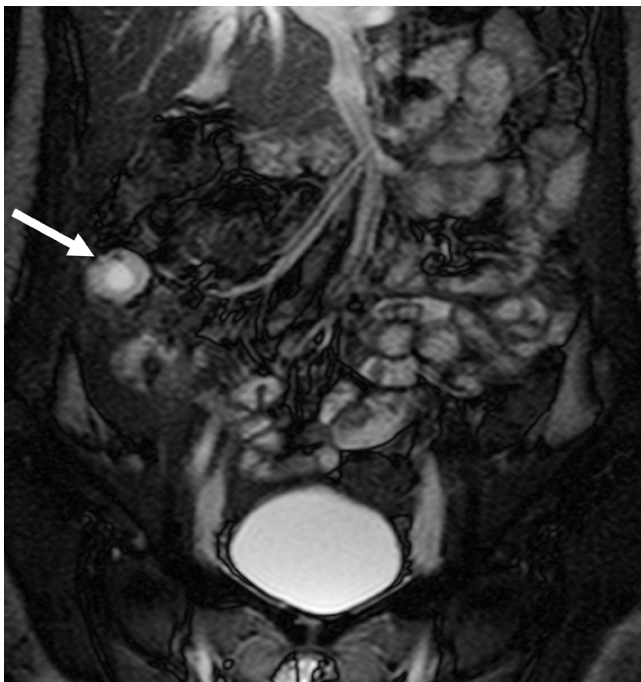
MR imaging finding in a 28-year-old woman with abdominal EP. Coronal T2-weighted imaging shows a well-defined cystic lesion with a thick peripheral wall (arrow) in the lateral aspect of the ascending colon, suggested to be the focus of the EP. Adapted from Kim et al. *Abdom Radiol (NY)* 2022;47:2254-2276, with permission of Springer Nature (20). EP = ectopic pregnancy
